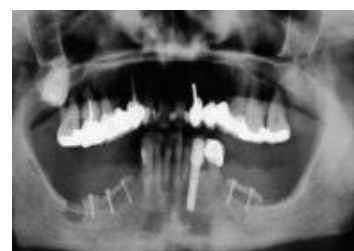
CT scan after autograft surgery, the autograft was adapted and fixed in the donor area with titanium screws
